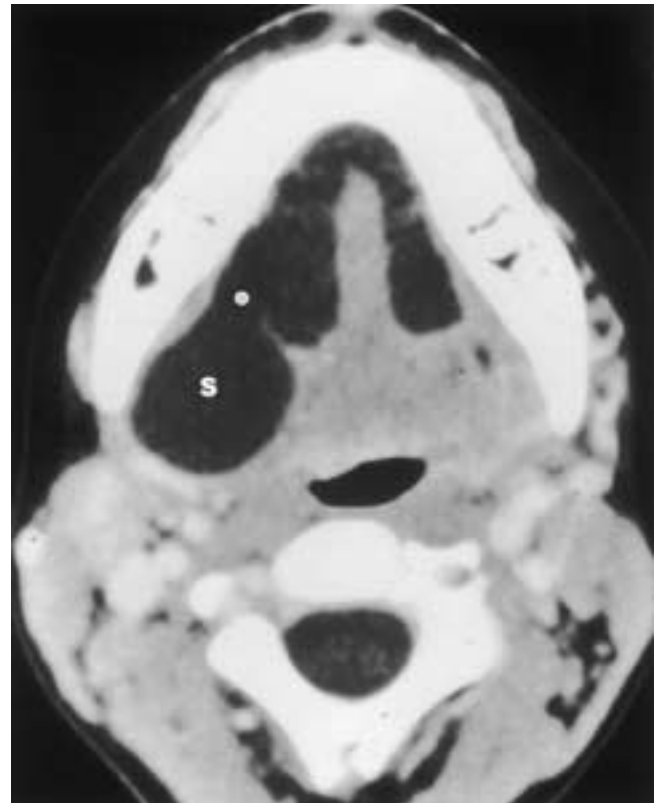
Diving ranula. Axial CT scan performed with contrast enhancement demonstrates a diving ranula on the right; the bulk of the ranula is centered within the deep aspect of the right submandibular space (S), with a ‘tail’ extending anteriorly into the right sublingual space (*dot*). The ranula has dissected across the midline, between the fibers of the mylohyoid and geniohyoid muscles, to be visualized within the left sublingual space.
